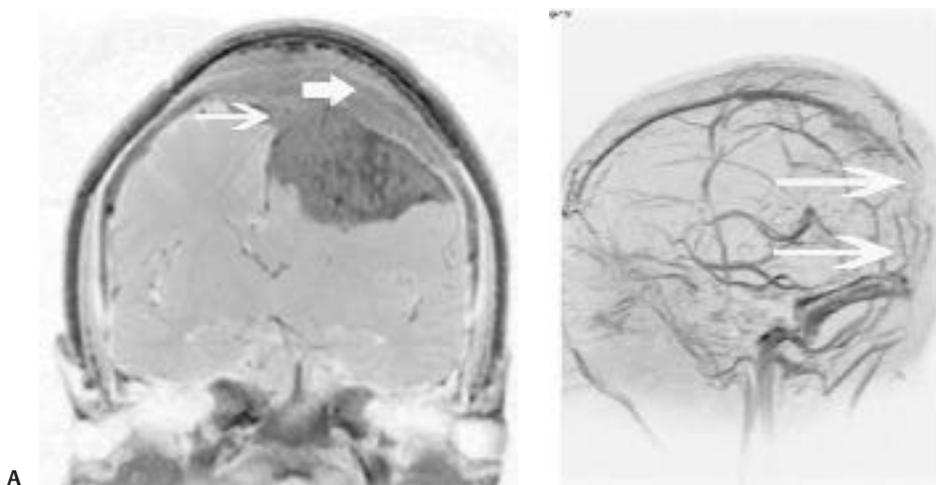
(A) Coronal postgadolinium magnetic resonance image demonstrates an atypical parasagittal meningioma with sagittal sinus invasion. This tumor crosses the midline and infiltrates the calvarium. (B) Magnetic resonance venogram demonstrates absent/decreased flow in the sagittal sinus (*arrows*).
